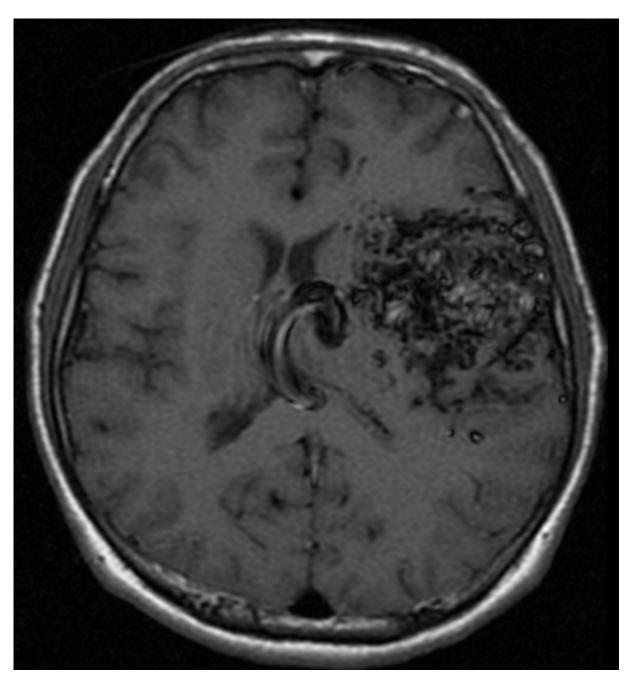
T1-weighted axial MR scan of left hemisphere AVM SM V, involvement of eloquent areas.
